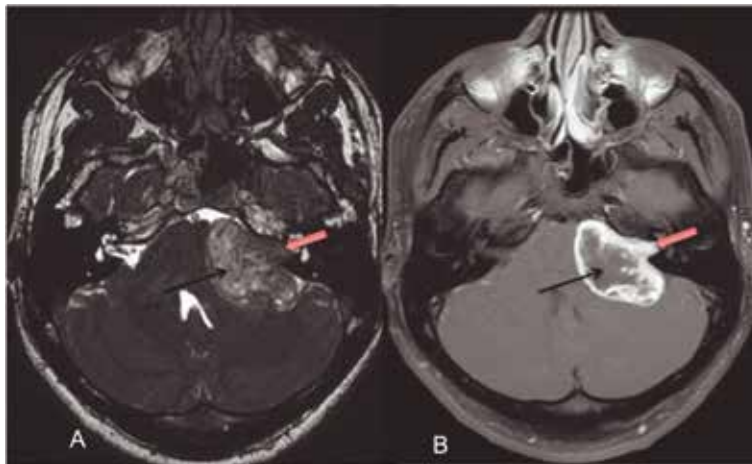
Large vestibular schwannoma. (A) T2-weighted image showing a solid (red arrow) and cystic tumor (black arrow). (B) Post-contrast-weighted image exhibiting intense contrast enhancement in the solid portion (red arrow) and heterogeneous pattern in the cystic component (black arrow).
